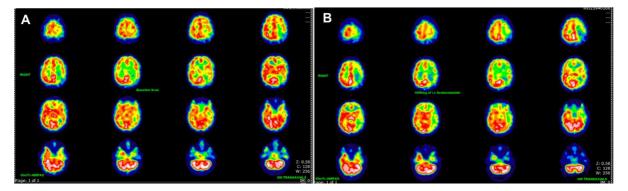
NM Brain HMPAO (Ceretec) SPECT Brain Scan. (A) The baseline study demonstrates slightly reduced perfusion in the left hemisphere compared to the right, but most pronounced in the parietal lobe. (B) Following acetazolamide there is a mild reduction in the global cerebral blood flow compared to the cerebellum. There is also a relative shift towards the right hemisphere suggestive of a steal phenomenon from the left hemisphere. This is an abnormal study consistent with moyamoya with reduced cerebral blood flow and impaired cerebrovascular reserve in both cerebral hemispheres but the changes are more marked on the left.
